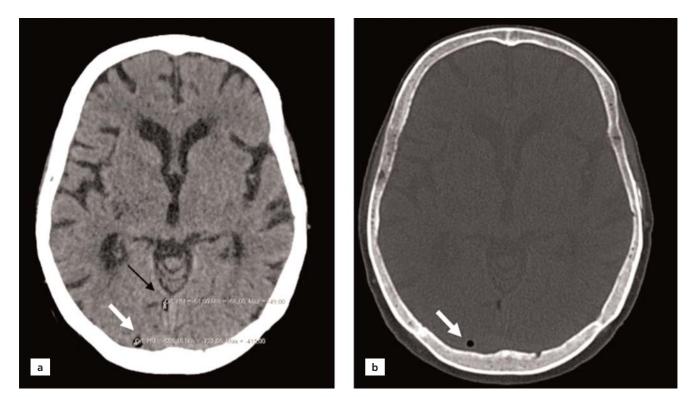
Parenchymal window (a) and bone window (b) images of non-enhanced cranial CT showing air bubbles in the transverse sinus (white arrows). A small midline lipoma is pointed by black arrow.
